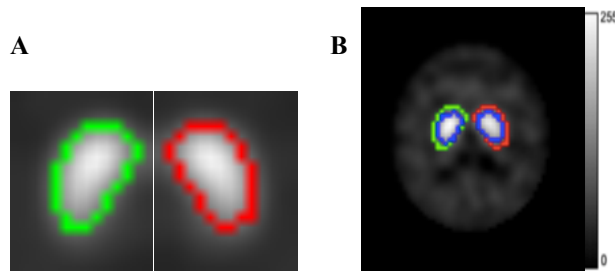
A) Normal SPECT striatum template from left (red) and right (green) striatum. B) Automatic placement of the normal templates (red and green) based on the centroids of each striatum of a DaTSCANTM study (blue)
